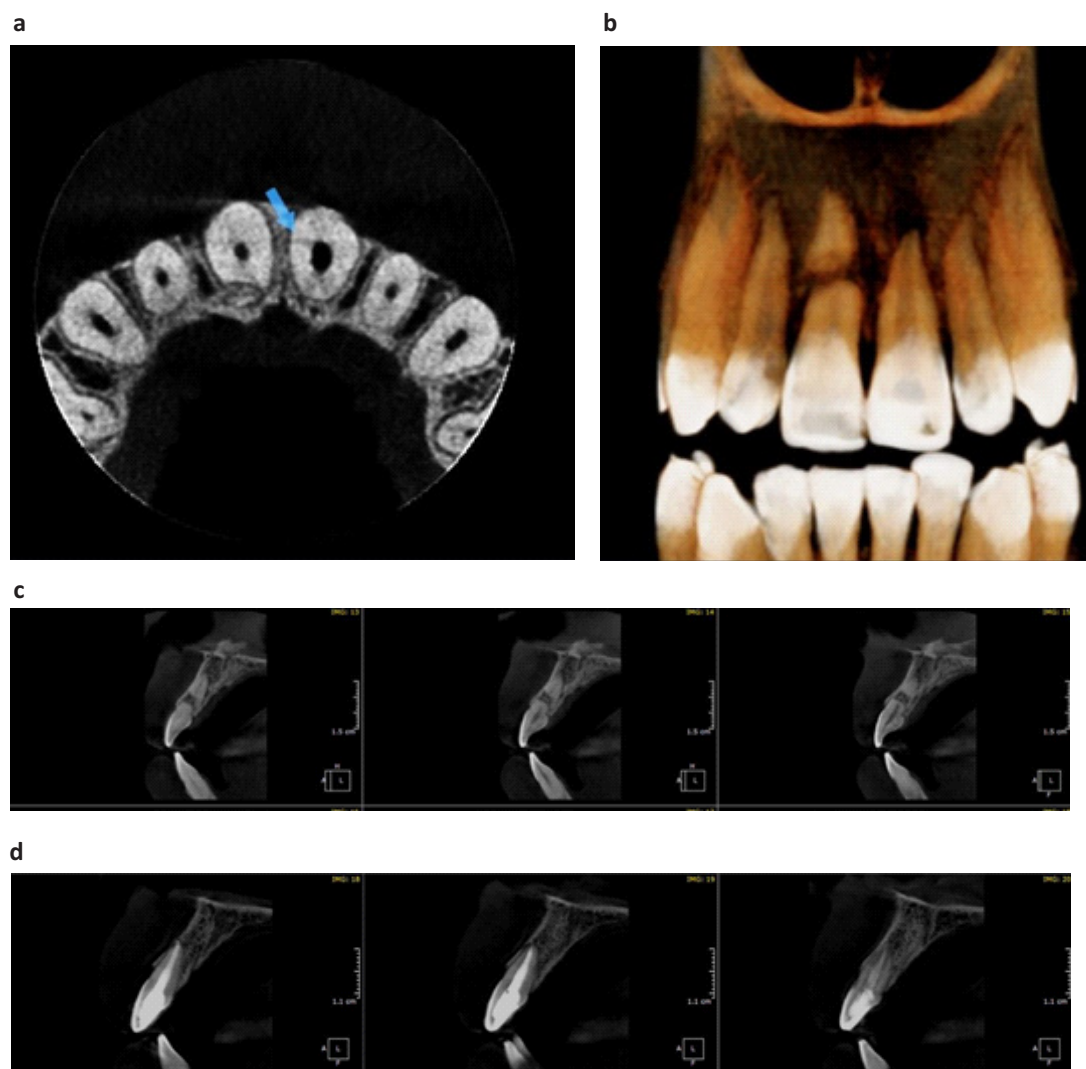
a) CBCT cross-sectional image of the coronal portion of the maxillary anterior roots, showing a root crack in tooth 21. b) Frontal reference of the tomographic image of the maxillary anterior teeth, revealing periapical radiolucency in tooth 21, as well as separation between the apical and coronal fragments of tooth 11 after consolidated fracture. c) CBCT sagittal section showing the lesion and initial fracture. d) Sagittal section after follow-up.
